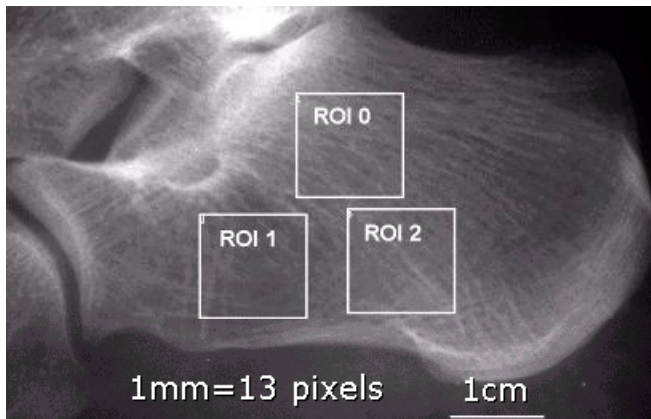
The three ROIs analyzed on each X-ray
